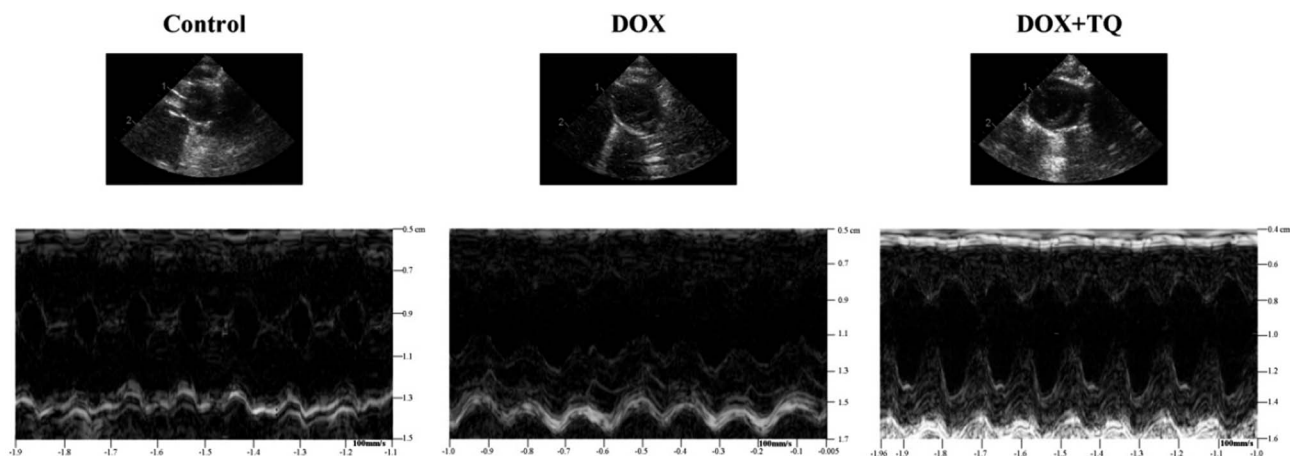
Representative M-mode echocardiographic tracings.
